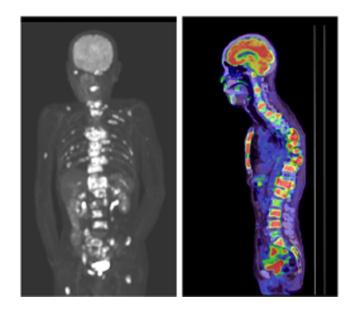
PET-CT showing fluorodeoxyglucose accumulation in the vertebrae, sternum, ribs, ilium, and femurs. No extraskeletal accumulation is observed
